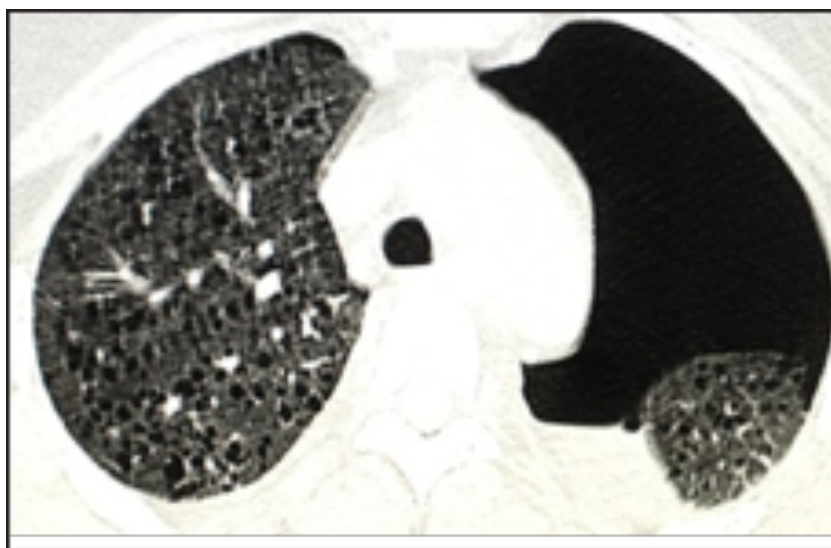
Computed tomography of the chest showing pneumothorax on the left and multiple cysts in both lungs.
